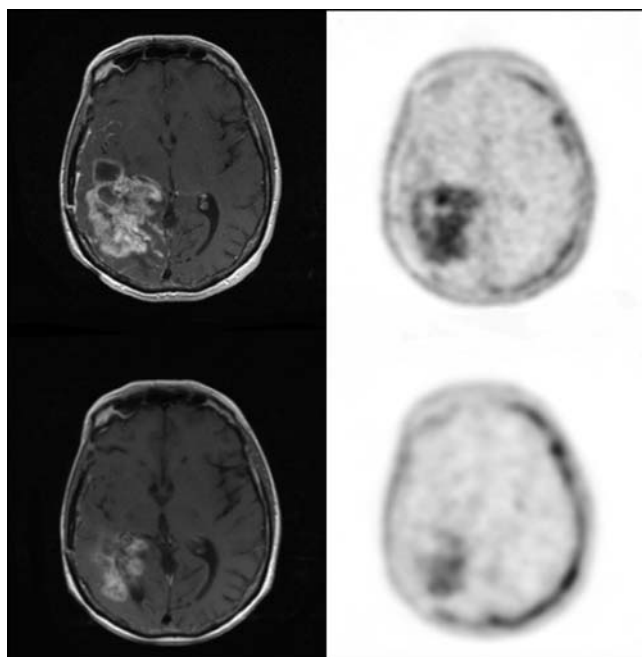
Status before (top) and response after (bottom) treatment with bevacizumab and irinotecan therapy for malignant brain tumor was assessed with MR imaging at 3 months (left) and with ^{18}F -FLT PET at only 1 week (right). ^{18}F -FLT PET was able to distinguish responders from nonresponders much earlier.
